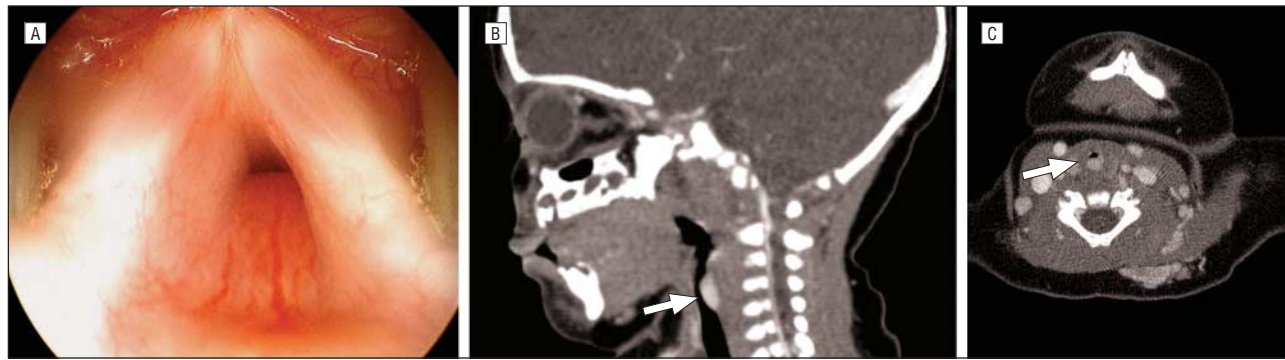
Posterior airway infantile hemangioma. A, Endoscopic view of a posterior airway infantile hemangioma. B, Sagittal computed tomographic angiogram demonstrating a localized enhancing mass (arrow). C, Axial computed tomographic angiogram demonstrating an enlarging mass in the posterior laryngeal airway (arrow).
